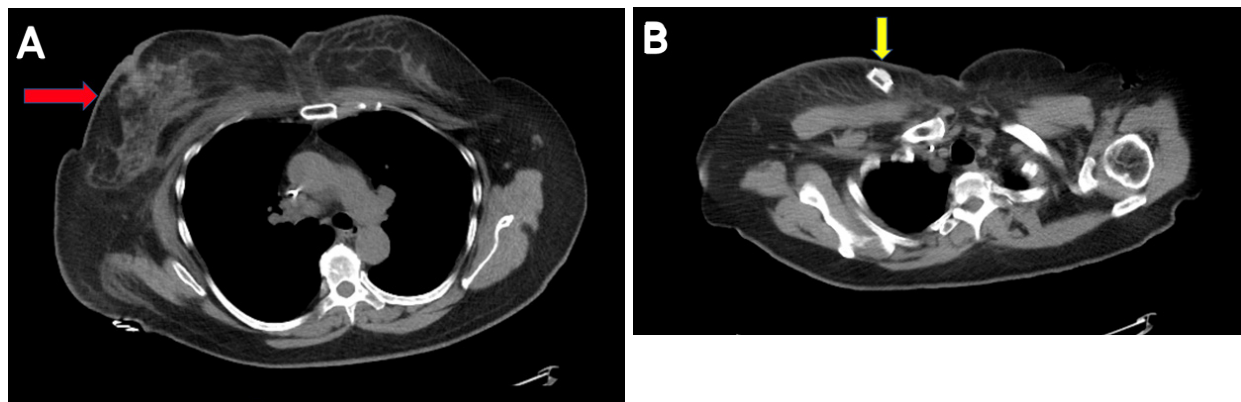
An axial view CT scan of the chest shows, A. right-sided cellulitis of the breast and chest wall (red arrow), and B. the port lying obliquely under the skin (yellow arrow).
